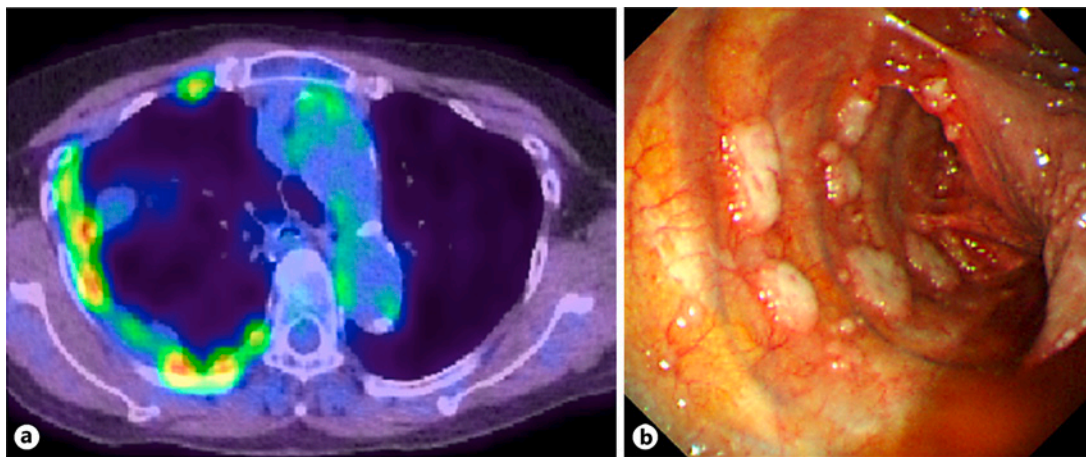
PET/CT image demonstrating the abnormal uptake of FDG on the right side of the pleura (a), and thoracoscopic exploration revealing multiple elevated lesions on the parietal pleura (b).
